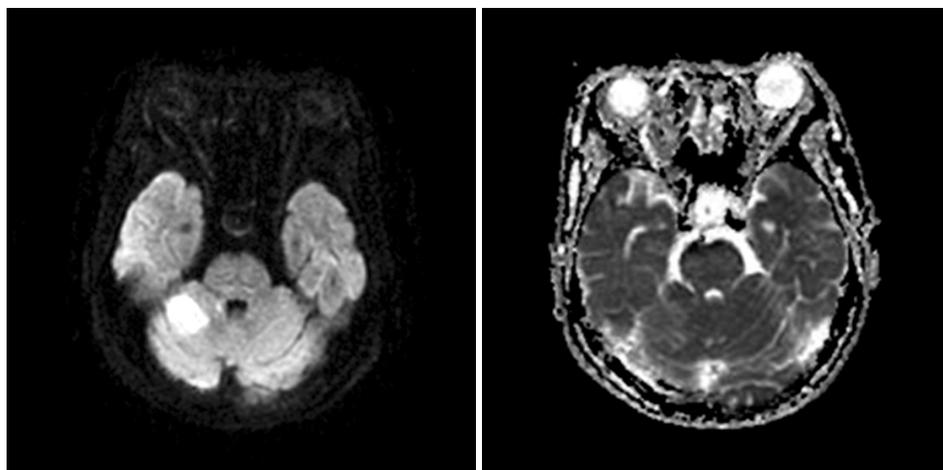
Axial T1-weighted image showed a high signal intensity lesion (Left) and the T2-weighted image showed a low signal intensity lesion (Right) in the right cerebellum.
